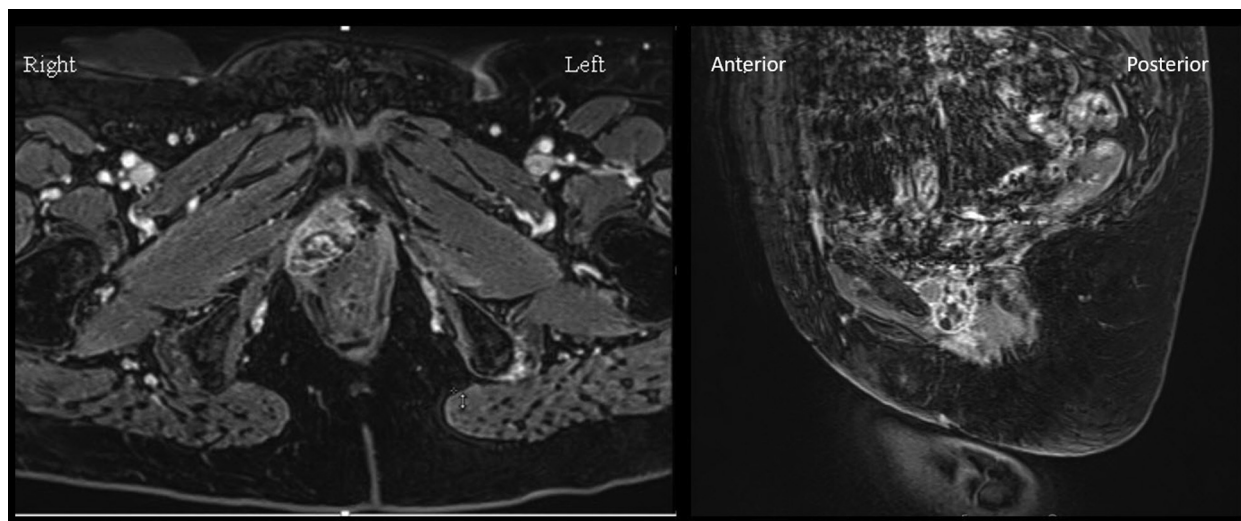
Magnetic resonance imaging (T1 postcontrast sequence) of recurrent urethral carcinoma. The recurrent mass was just anterior to the vaginal remnant and posterior to the pubic bone.
